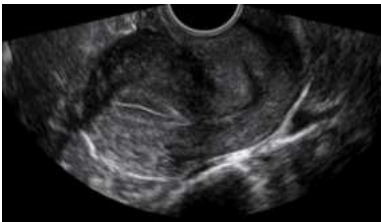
21-year-old female, Transvaginal sonography (TVS) shows a well-defined trilaminar endometrium measuring 11 mm in thickness. The endometrium displays the characteristic triple-line appearance, with a central echogenic stripe flanked by two hypoechoic zones.
